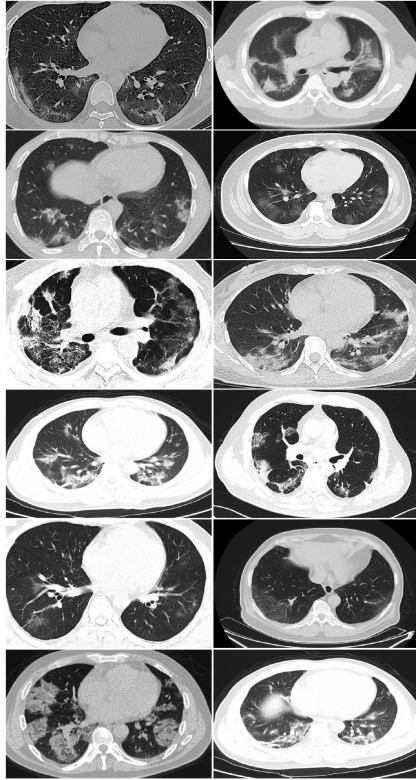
CT scan samples of positive COVID-19 in dataset. The phenomenon of ground glass cloudy in the lungs and pleural effusion is obvious.
